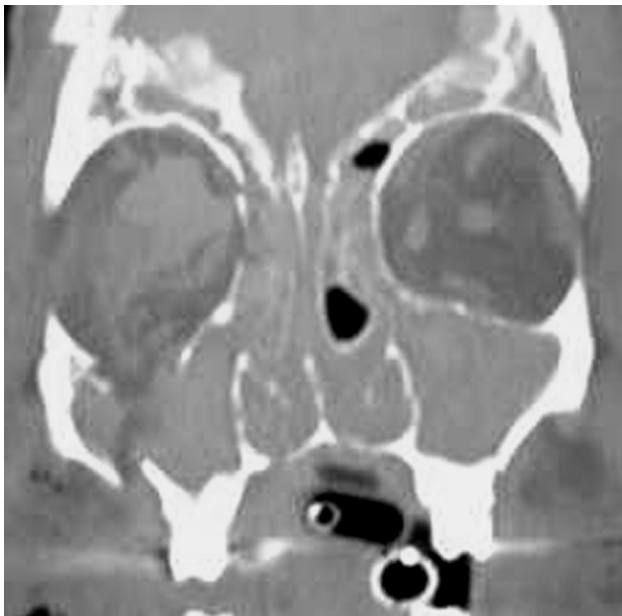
CT scan-coronal view
